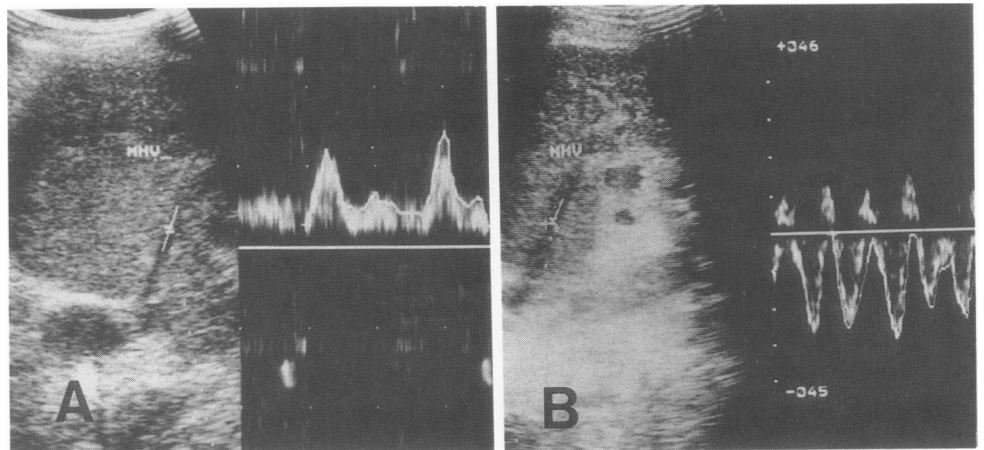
Doppler signals from the middle hepatic vein in patient 2 are demonstrated. Spectral Doppler analysis in the middle hepatic vein when intra-abdominal hemorrhage developed in the patient, which revealed blood flow toward to the source of the Doppler beam, indicating that the blood in the middle hepatic vein was flowing away from the inferior vena cava (A). After the hemorrhage was controlled, the blood flow direction recovered to normal (toward the inferior vena cava) (B).
